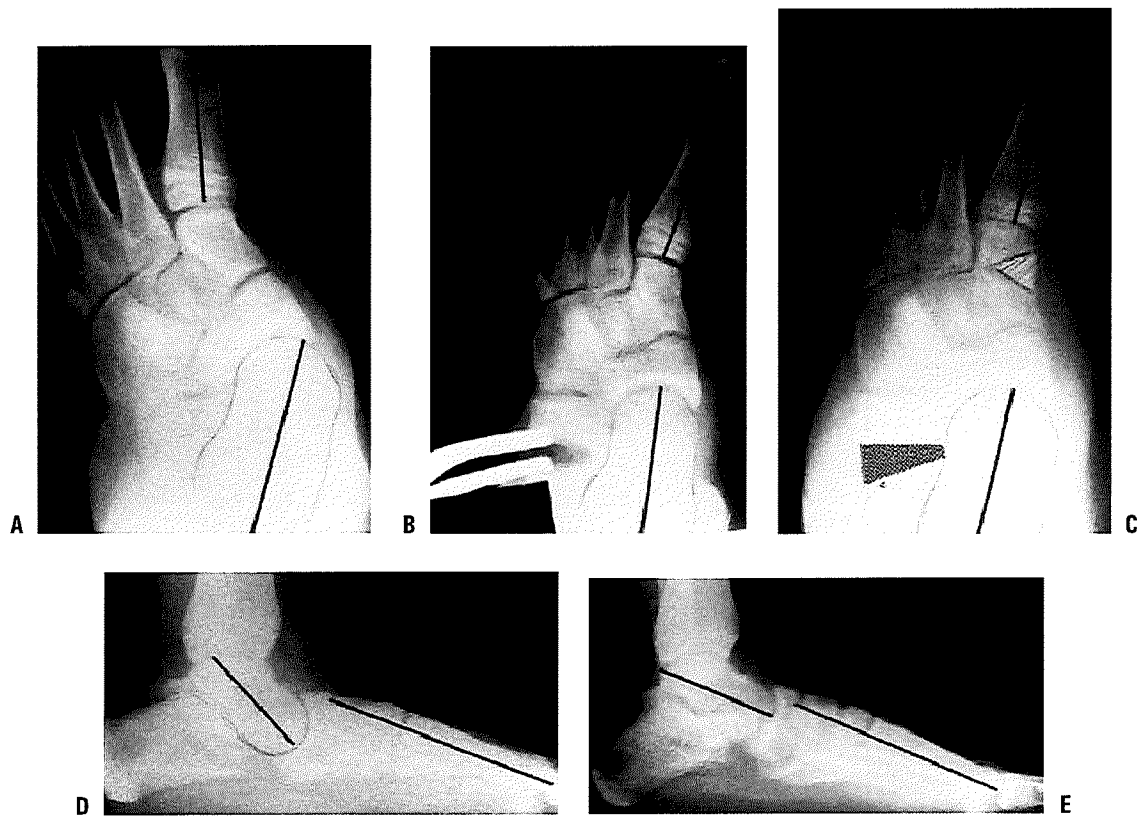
Preoperative, intraoperative, and postoperative radiographs of a painful skewfoot in a 13-year-old adolescent. A: Preoperative anteroposterior view. B: Intraoperative distraction of calcaneal osteotomy. C: Corrected deformity on anteroposterior radiographs with grafts in place. D: Preoperative lateral view. E: Postoperative correction. Calcaneal lengthening osteotomy, medial cuneiform opening-wedge osteotomy, and Achilles tendon lengthening were used. (From Mosca VS. Flexible flatfoot and skewfoot. In: Drennan JC, ed. *The child's foot and ankle*. New York, NY: Raven Press, 1992:355, with permission.)
